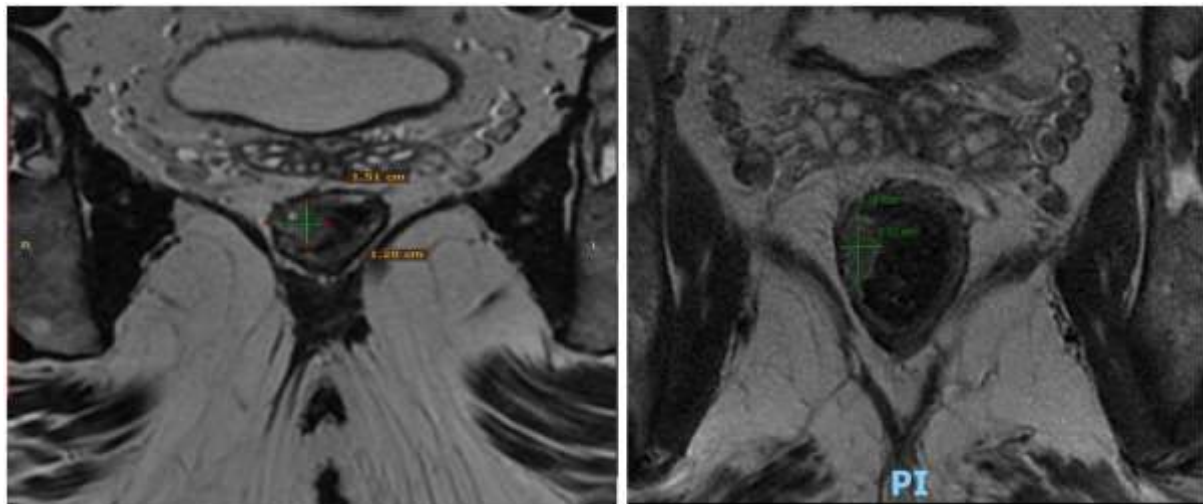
a) T2 axial plane (06/04/2021) without procedures, only with ozone therapy, had already started ozone therapy before the first MRI; b) Axial T2 plane (06/21/2021) post-treatment with ozone therapy: Significant axial decrease in tumor size.
